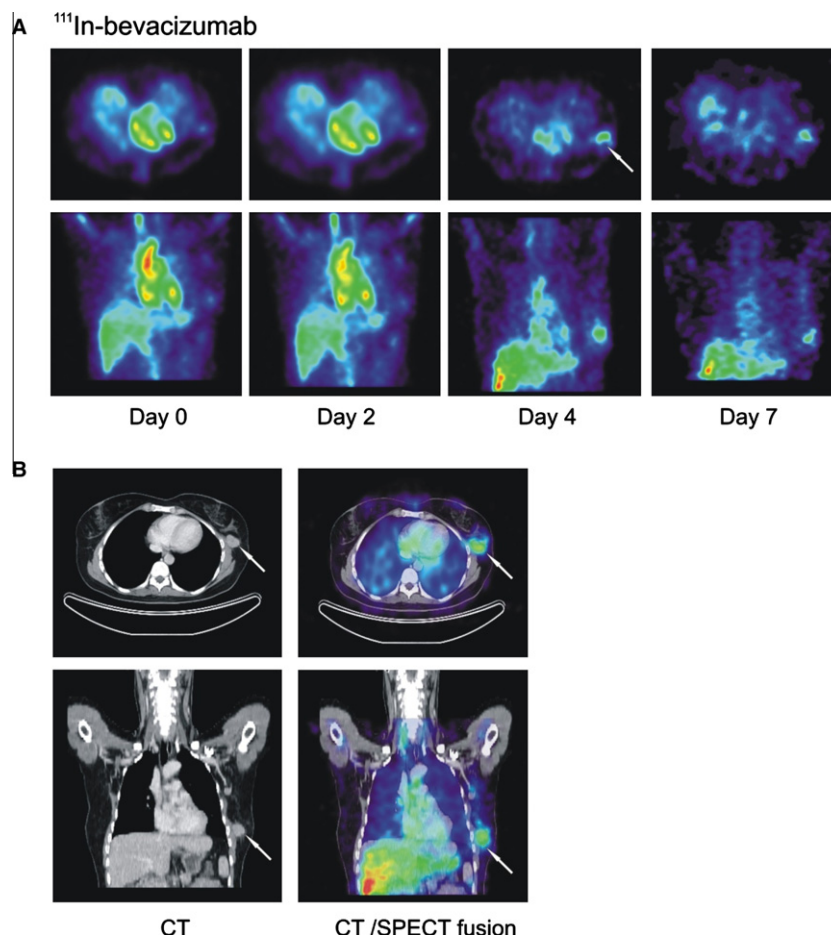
(A) Transversal and coronal VEGF-SPECT images at days 0, 2, 4 and 7 post injection of the tracer. Over time, ¹¹¹In-bevacizumab accumulates in the tumour with optimal tumour to background ratio 4 days post injection. (B) Transversal and coronal CT images and VEGF-SPECT/CT fusion 4 days post injection.
